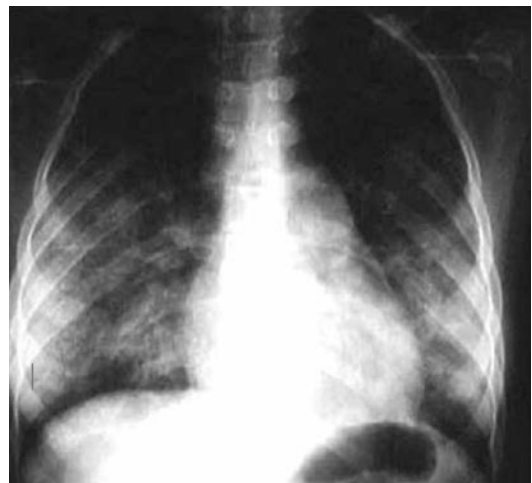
Chest x-rays showing idiopathic pulmonary hemosiderosis (IPH) in a 13-year-old girl with an active hemorrhage, showing cottony, bibasilar, symmetrical forms without compromise of the lung apices and costophrenic angles
